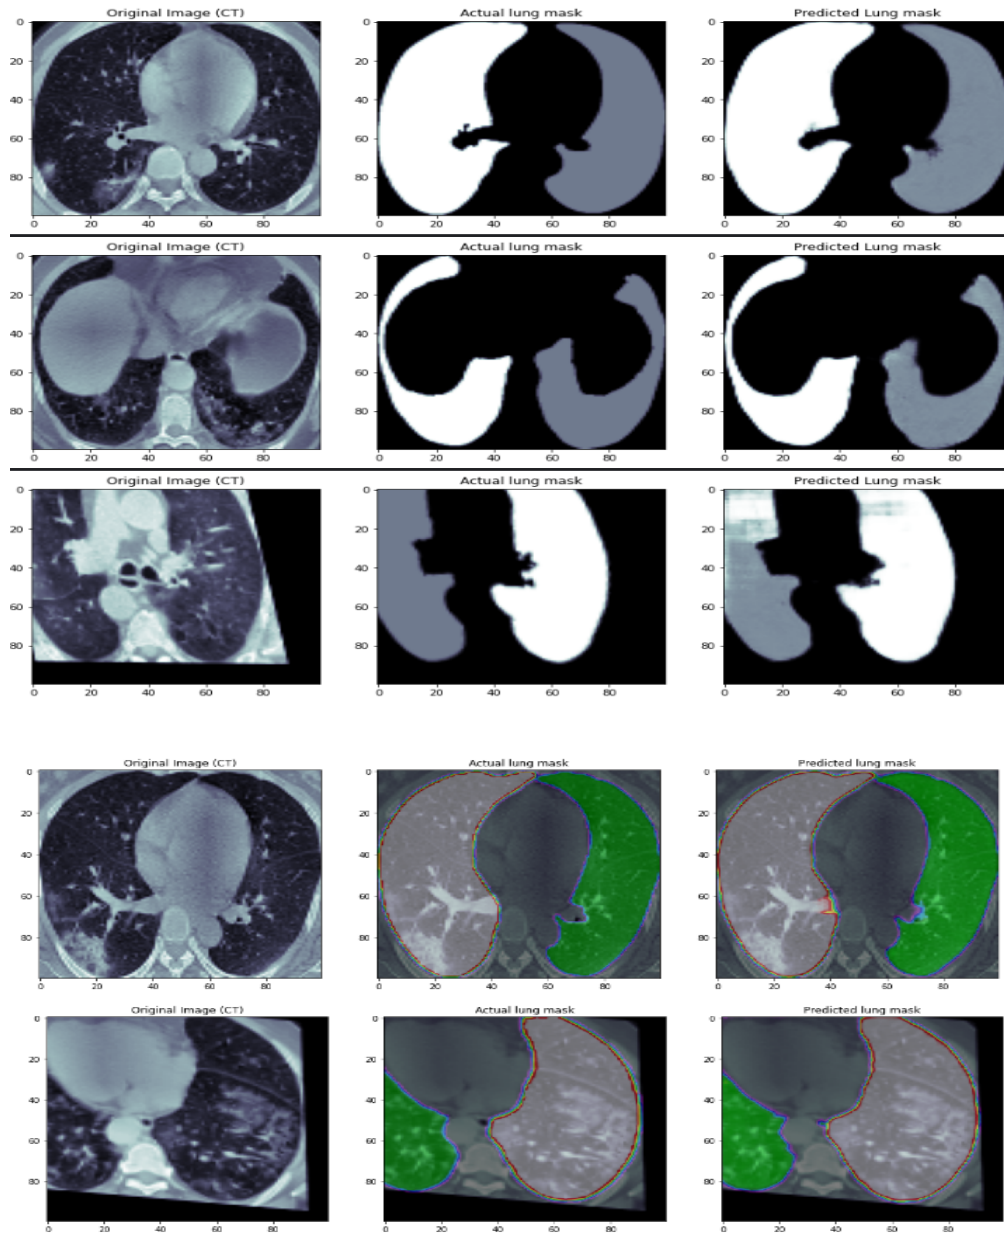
Qualitative evaluation of the proposed U-net model performance on COVID-19 CT images.
